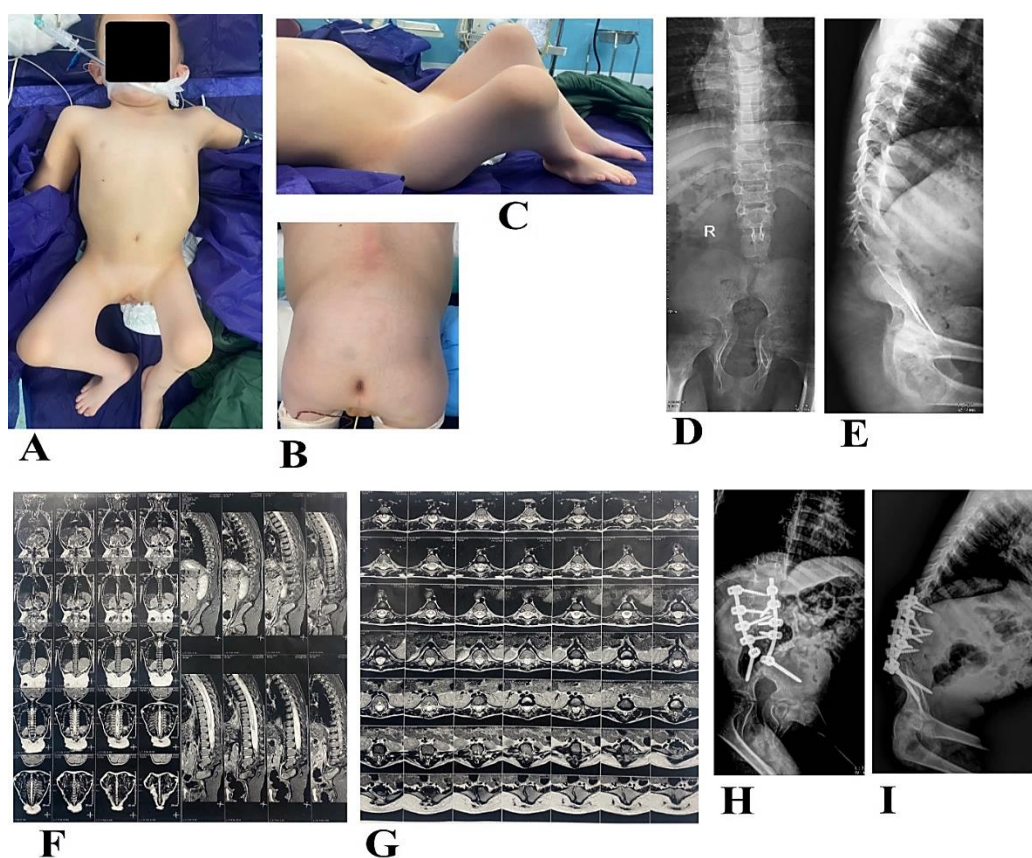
A, B, C) Preoperative photography; D, E, F, G) Preoperative radiographies and magnetic resonance imaging (MRI); H, I) Postoperative radiographies
